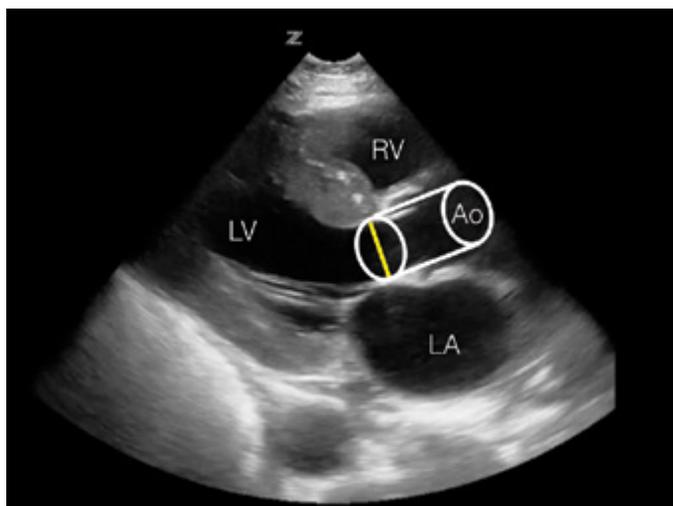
Projection of the estimated stroke volume cylinder onto the parasternal long axis view. The measured LVOT diameter can be seen as a yellow line. RV = right ventricle, LV = left ventricle, LA = left atrium, Ao = Aortic outflow tract
